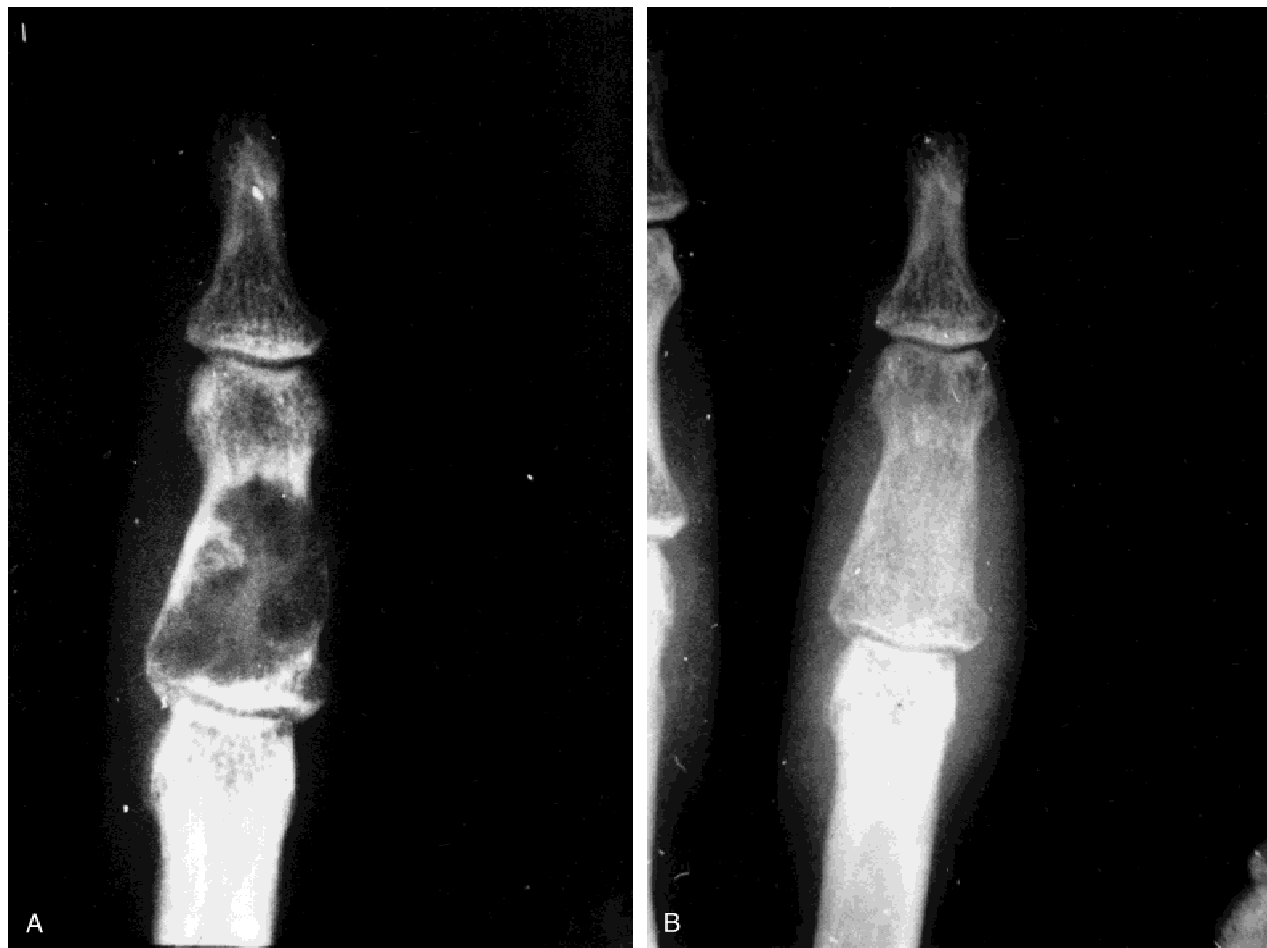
A: A 38-year old female presented with painful swelling in the index finger. X-rays showed a multiloculated lytic lesion involving the metaphysis and diaphysis of the middle phalanx. The cortex on one side is ballooned-out, very thin and expanded. B: Following curettage CO₂ Laser treatment and bone grafting the patient's symptoms resolved. X-rays at follow-up showed incorporation of the bone graft and no evidence of tumor recurrence.
